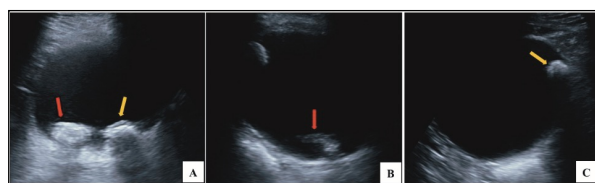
(A-C): Ultrasonographic images of the urinary bladder. Transverse ultrasonographic images of the urinary bladder in supine position (A), and sagittal images on left (B) and right (C) lateral decubitus positions show two echogenic structures, one each on the right (red arrows) and left (yellow arrows) sides, within the lumen of urinary bladder showing posterior acoustic shadowing, representative of calculi. A thin echogenic rim of soft tissue is seen around the calculus on the left (yellow arrows). The calculus on the left side shows no change in position with the change in patient decubitus, while the calculus on the right (red arrows) shows displacement to the dependent position.
